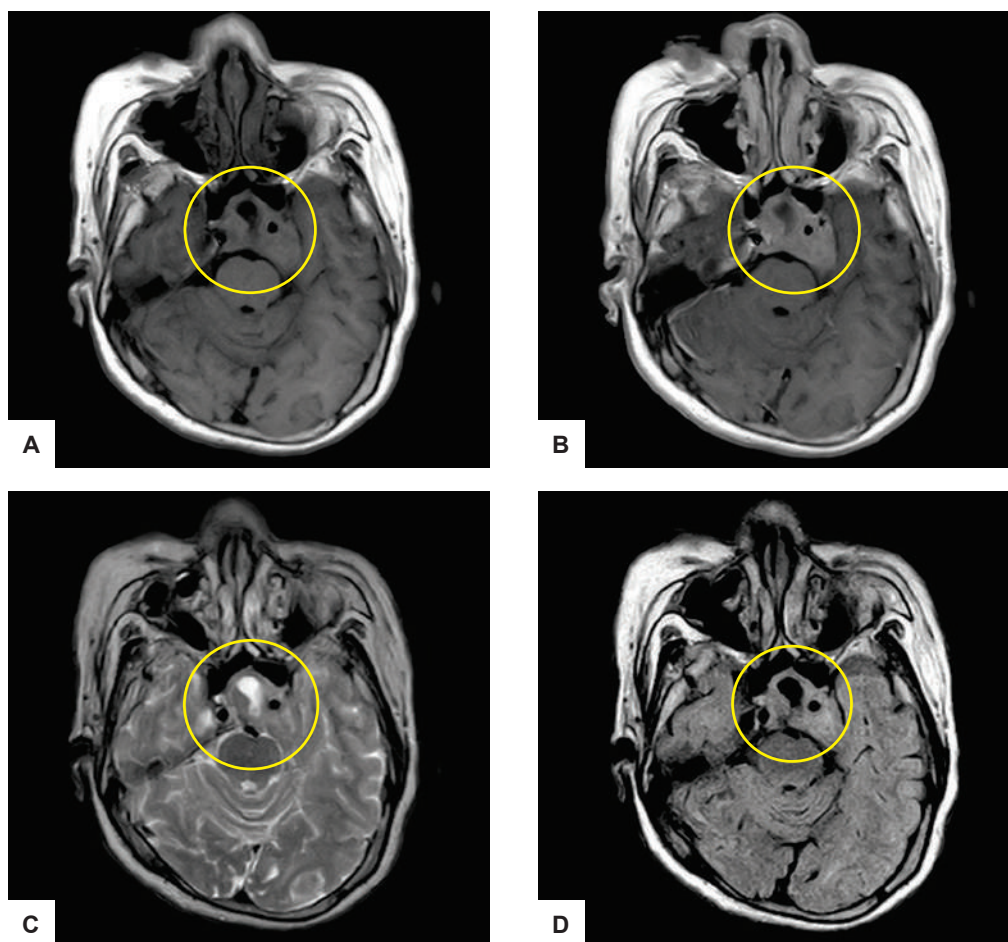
Cranial Magnetic Resonance Imaging (MRI). A 2.2x3.1x3.1 cm poorly defined complex mass predominantly solid in the sella with extension to left parasellar region. (A) T1 Weighted Image (T1WI) – Isointense (B) T1 contrast image – Isointense (C) T2 Weighted Image (T2WI) – Mixed Signals (D) Fluid Attenuation Inversion Recovery (FLAIR) post gadolinium study - homogenous contrast enhancement. Noted encasement of the cavernous portion of the left carotid artery and bony destruction of the left petrous apex bone.
